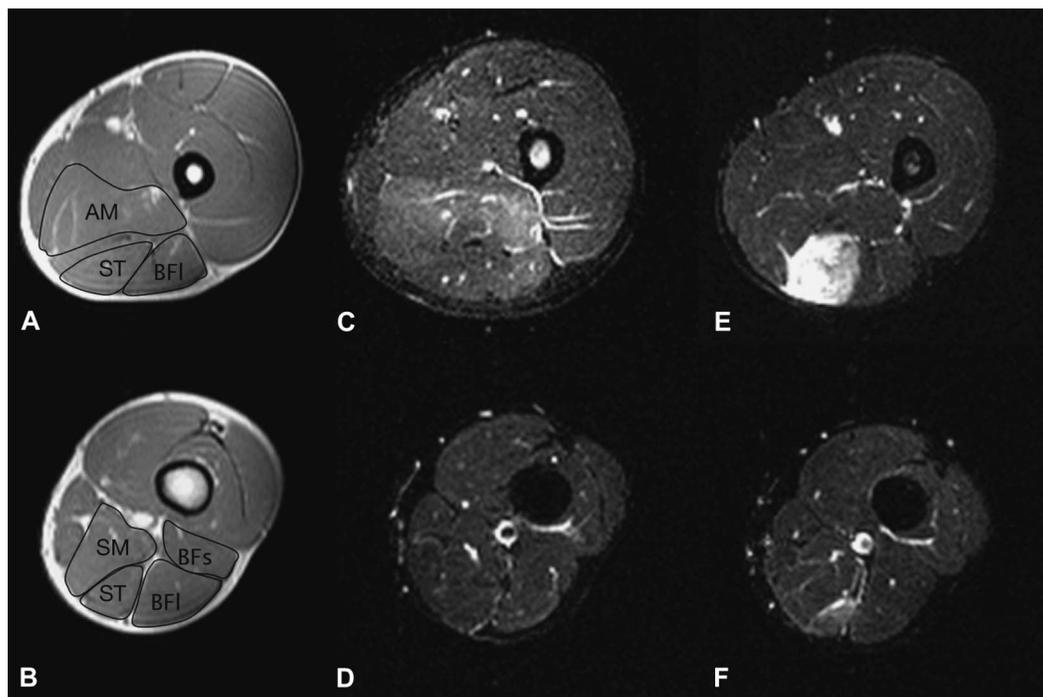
Representative DP-weighted (A, B) and short tau inversion recovery (STIR) magnetic resonance images of the thigh at L_7 (first row A–C) and L_{10} (lower rows E, F) obtained after lunge (B, D) and eccentric leg-curl (E, F) exercise protocols. Note that at proximal thigh adductor magnus (AM) and biceps femoris long head (BFI) are brightened after lunge exercise (C), and semitendinosus (ST) after eccentric leg curl (E). At distal thigh ST shows increased signal intensity after eccentric leg-curl exercise. Semimembranosus and biceps femoris short head (BFs) muscles show no increased signal intensity.
